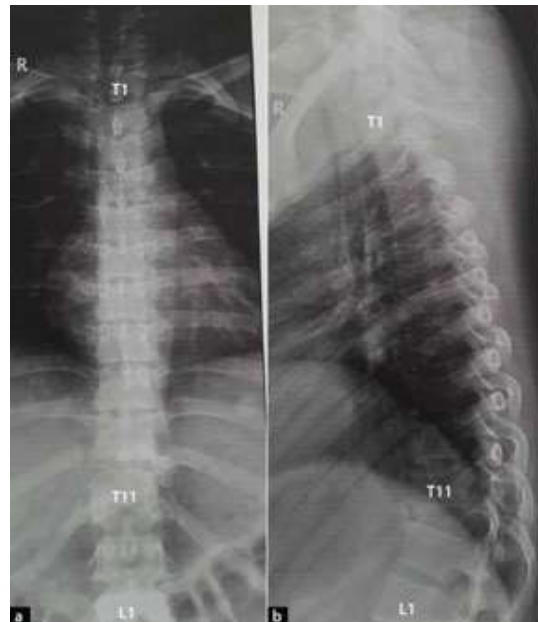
Initial, preoperative (a) anterior-posterior and (b) lateral X-ray.
